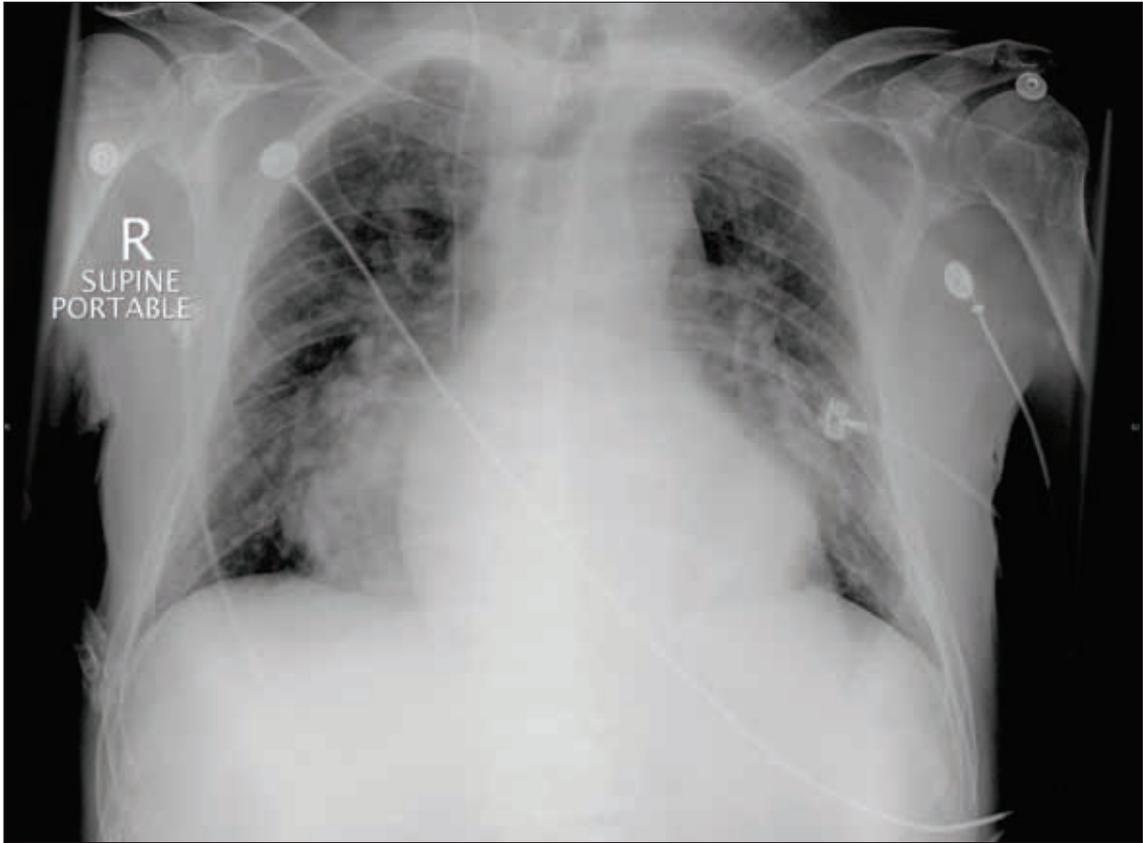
CVC chest X-ray
